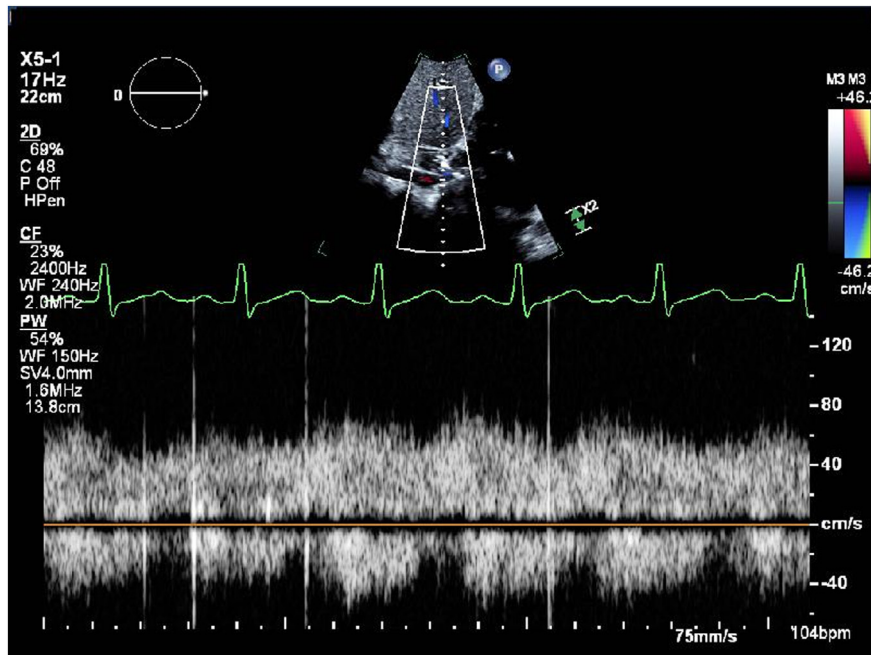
Two-dimensional TTE, abdominal aortic pulsed-waved spectral Doppler profile, demonstrates significantly abnormal Doppler pattern with blunted profile and forward flow in diastole.
